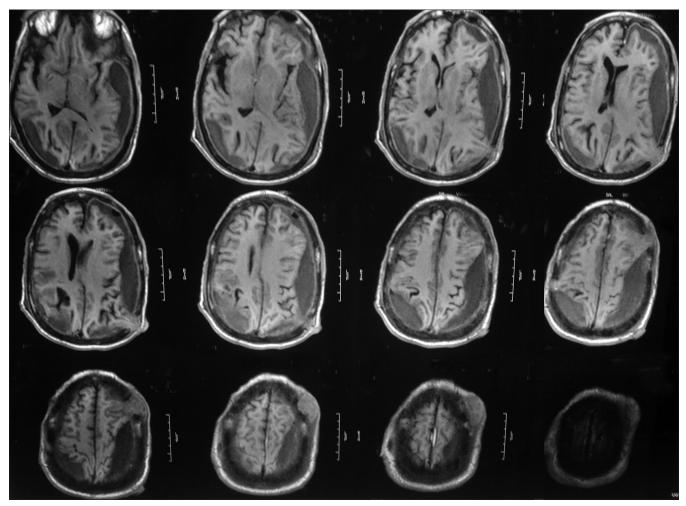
MRI Brain showing impaction and prolapse of brain parenchyma through burr hole site giving tiger hide appearance
